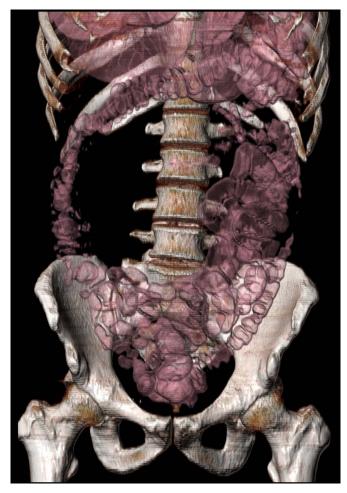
Computed tomography in 3D reconstruction showing the dislocation of the small and large bowel.
